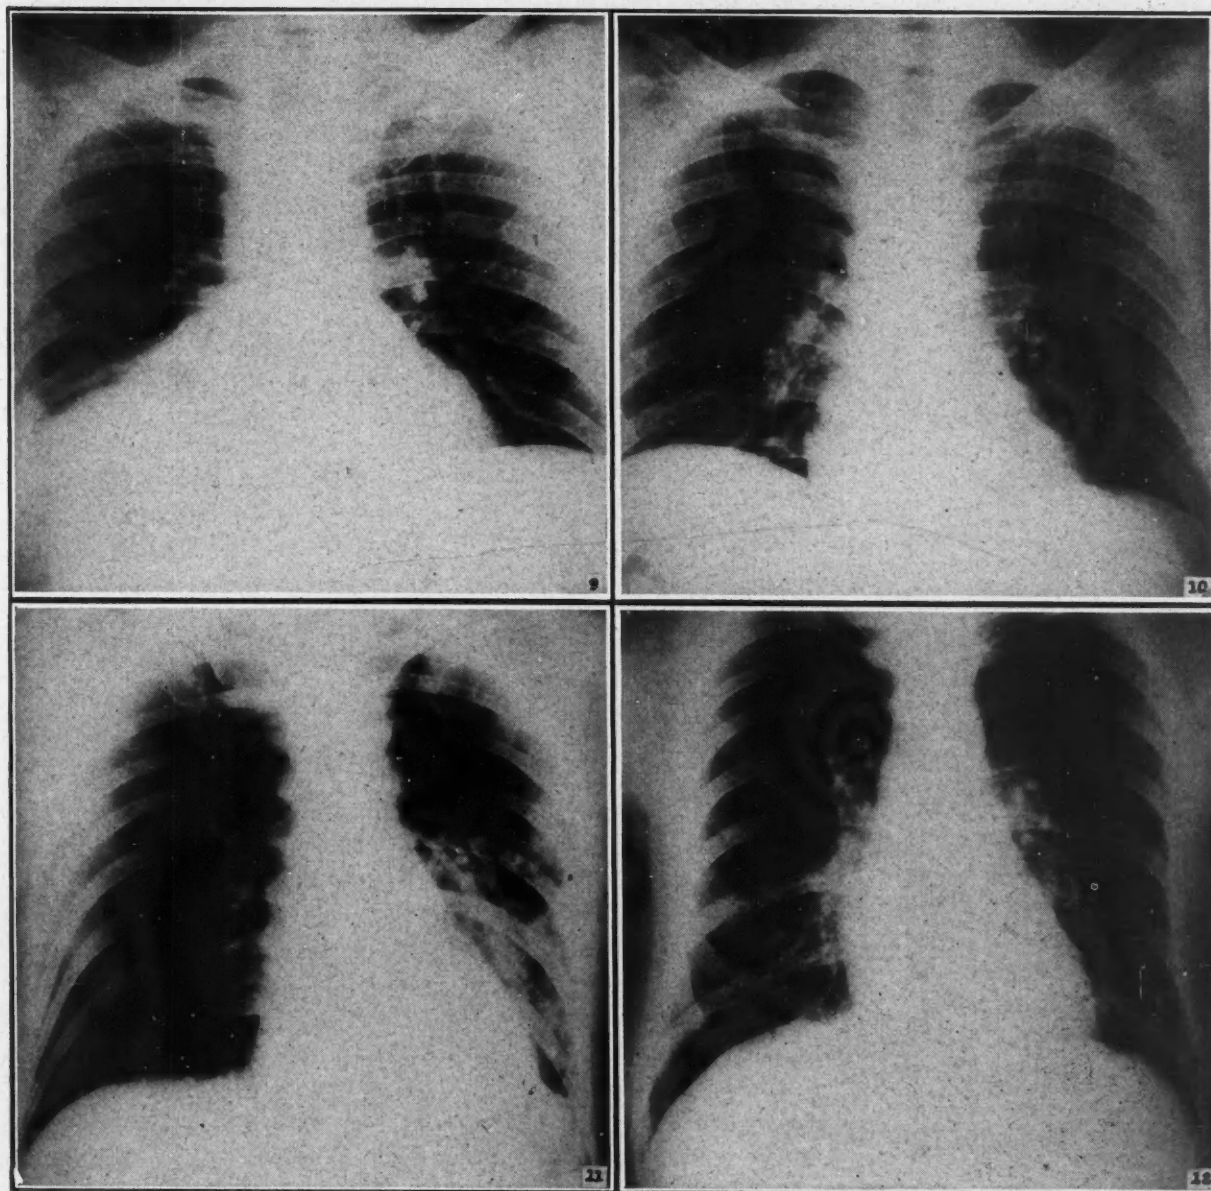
(Case 4).—X-ray taken May 29 shows the dense shadow at the right cardio-phrenic angle and the raised hemidiaphragm indicative of atelectasis. Fig. 10.—Shows the complete clearing in a plate taken May 30. Fig. 11. (Case 5).—X-ray of July 6 showing dense shadows in left lung and some shift of the heart to the left. Fig. 12.—Lung fields practically normal on July 10.
